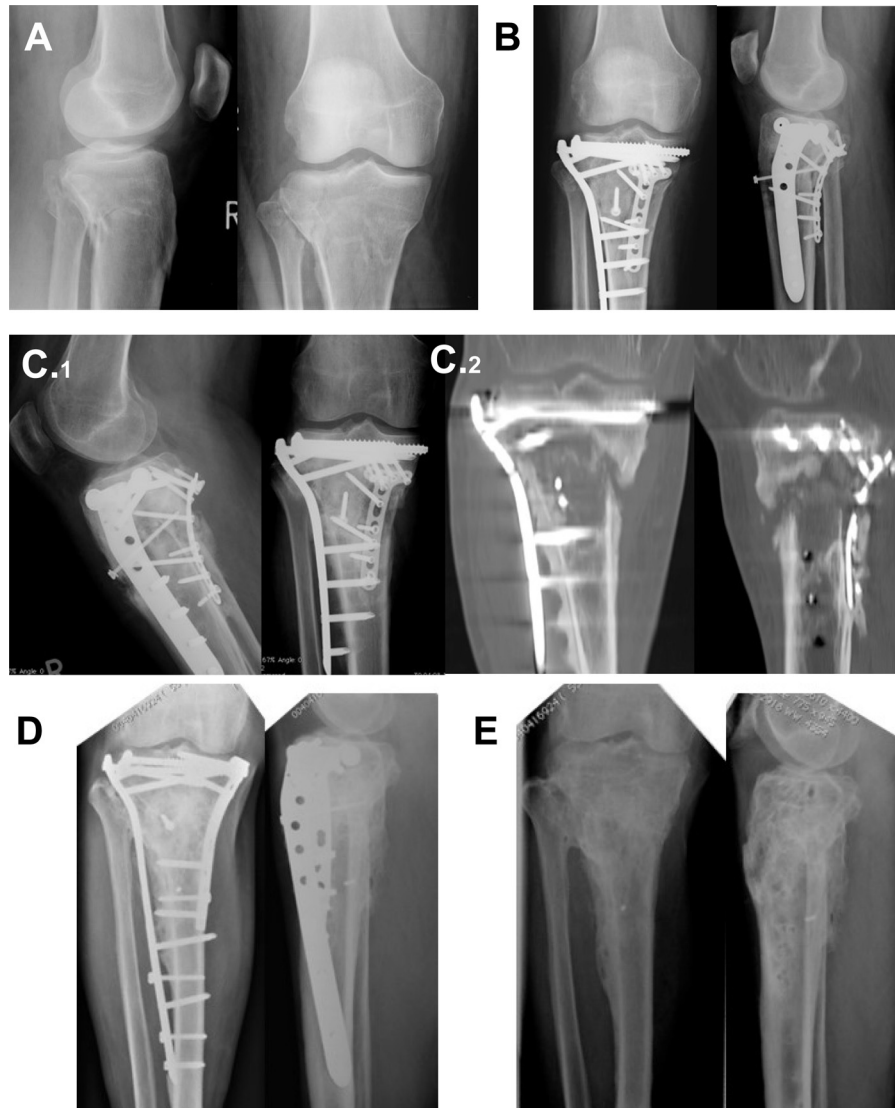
Successful treatment of a non-union with BMP2: A radiograph after fracture; B primary fracture treatment; C resulting non-union (C.1) with CT image in C.2; D healing after revision with re-osteosynthesis and BMP2; E implant removal.
